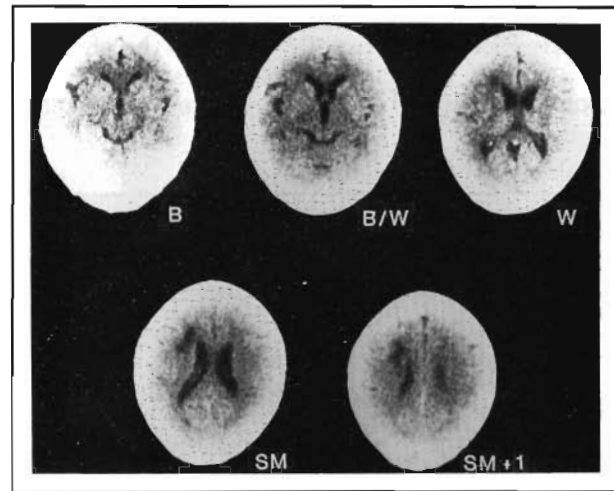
CT of classical TCMA case, in which frontal lobe lesion is anterolateral to the left frontal horn. Subcortical white matter lesion begins at slice W deep to left middle frontal gyrus area and continues with superior lesion extension, which is largest at slices SM and SM+1. There is no lesion in Broca's area (slices B and B/W); rather, lesion is deep and superior to Broca's area. Patient 4, aged 60, 7 days postonset.
